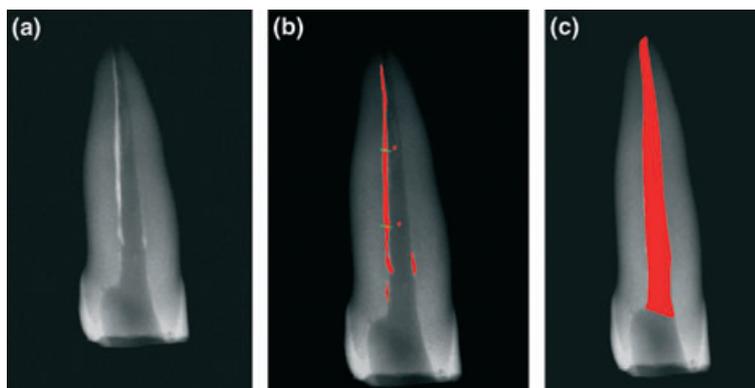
Radiographic analysis (a). Filling debris (b). Total area of the root canal (c).
